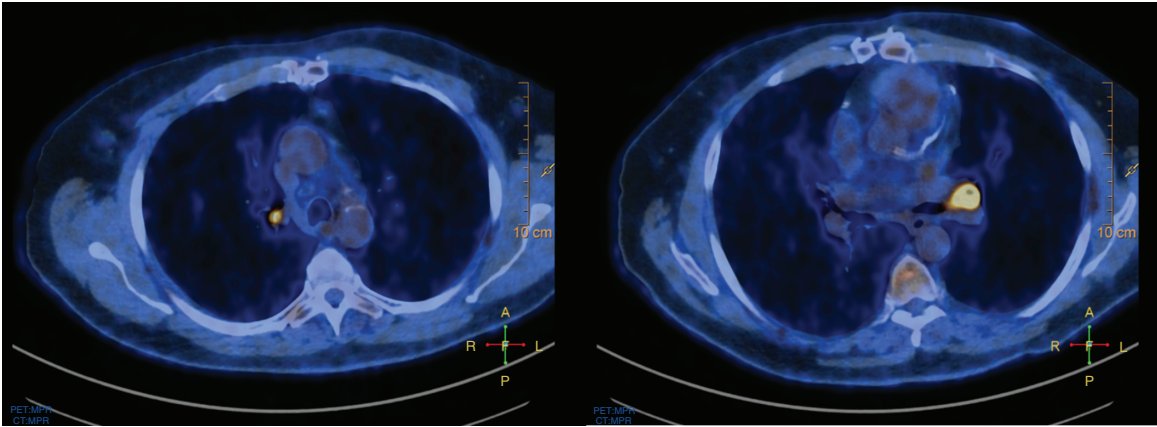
PET-computed tomography showing fluorodeoxyglucose avidity of both lesions of the left upper lobe lesion (right) as well as a right hilar lesion (left).
